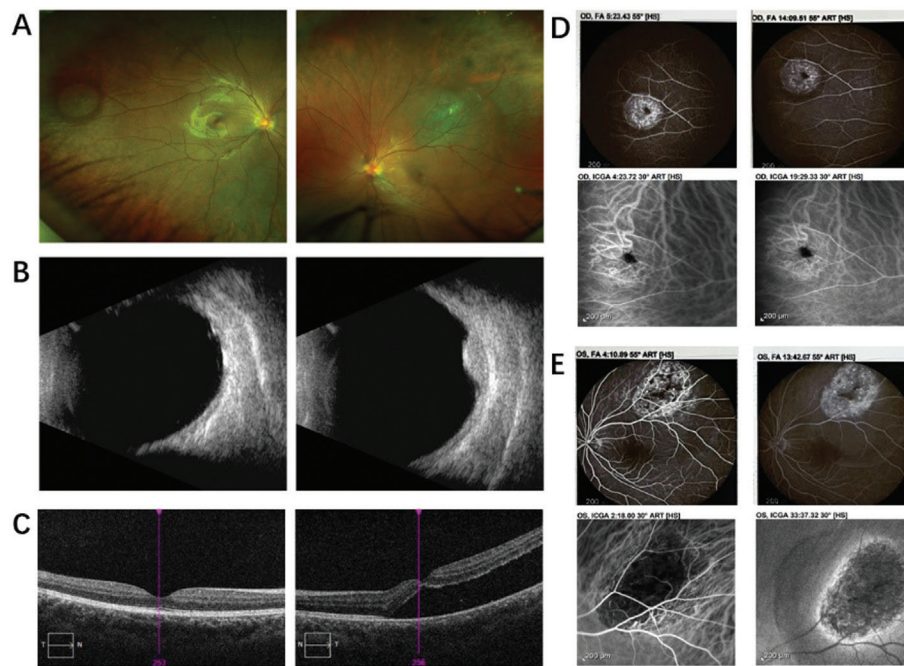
Images of case before treatment A: Scanning fundus laser photography of both eyes. B: B-ultrasound: No obvious abnormal echo in the right eye, and a hemispherical moderate uniform echo can be seen in the left eye. C: OCT: The shape of the retina in the macular area of the right eye was normal at presentation, and the neuroepithelial layer of the macular region of the left eye was detached. D: FFA of right eye showed irregular high fluorescence mixed with low fluorescence in the lesions. ICGA showed that round mottled strong fluorescence of the periorbic omentum of the temporal side of the right eye. E: Abnormal linear and granular high fluorescence within the lesion can be seen in the early left eye FFA while discoid fluorescence accumulation can be seen below the lesion in the late stage. ICGA of left eye showed that persistent high fluorescence was present in the early stage of the lesion, while low fluorescence was present in the late stage (flushing phenomenon) with a high fluorescence ring can be seen around the lesion. OCT: Optical coherence tomography; FFA: Fluorescein angiography; ICGA: Indocyanine green angiography.
